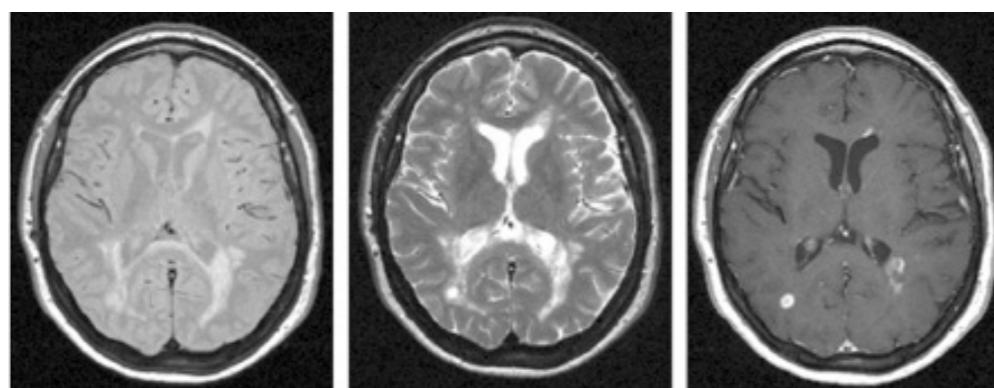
Axial (a) proton density-weighted, (b) T2 weighted and (c) gadolinium-enhanced T1 weighted spin-echo MR images of the brain in a 37-year-old patient with RRMS
